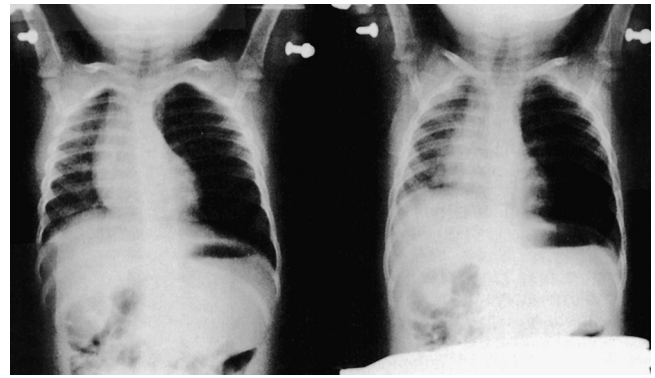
Foreign Body Aspiration. Inspiratory (left) and expiratory (right) chest radiographs of a child who aspirated a portion of a potato into the left main-stem bronchus. Left lung field is hyperaerated and the mediastinum is shifted to the right on expiration because of left-sided obstructive emphysema. (From Kenna MA, Bluestone CD: *Pediatr Rev* 10[1]:25, 1988.)
